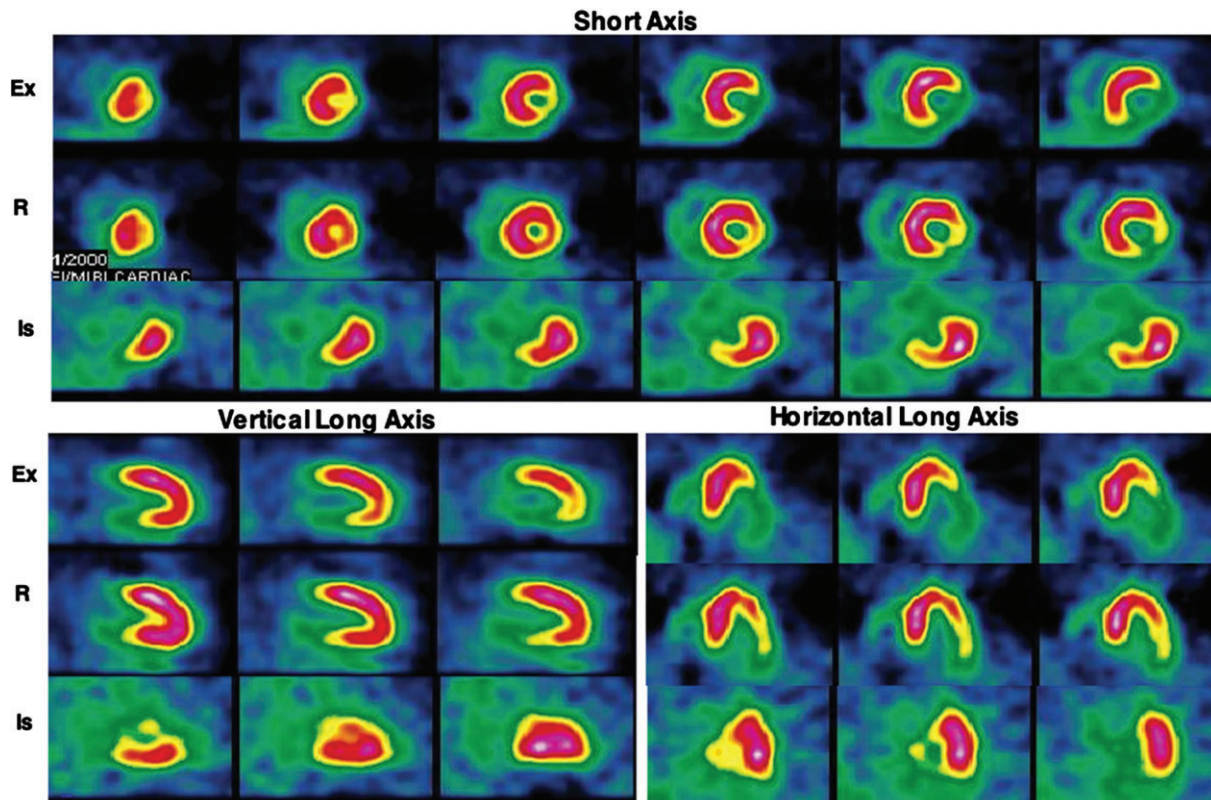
Representative exercise (Ex) and rest (R) technetium-99 m-sestamibi and exercise ^{18}F -fluorodeoxyglucose (^{18}FDG) images of a patient with angina in the short axis, and vertical and horizontal long axes. This patient had no history of myocardial infarction. A large area of partially reversible perfusion abnormality involving the inferior and lateral walls is seen on the perfusion images. Intense ^{18}FDG uptake is seen in the areas corresponding to the perfusion abnormalities. On coronary angiography, 100% occlusion of the right coronary artery and a 50% narrowing of the left anterior descending coronary artery were observed. Reproduced with permission from Jain and He.³⁴
